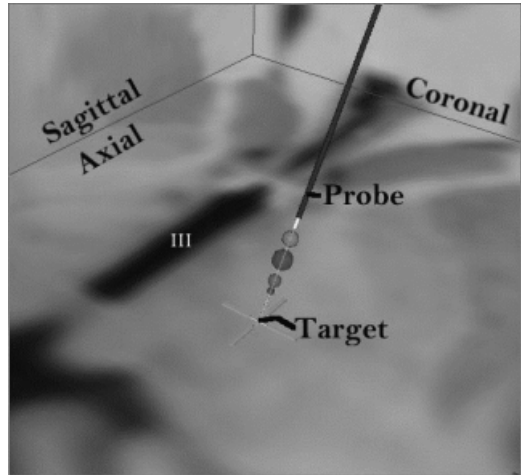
Probe (purple) registered to patient MRI with crosshairs (yellow) placed at target. Spheres indicate responses obtained with stimulation. Slice plane orientations indicated. III: 3rd ventricle
